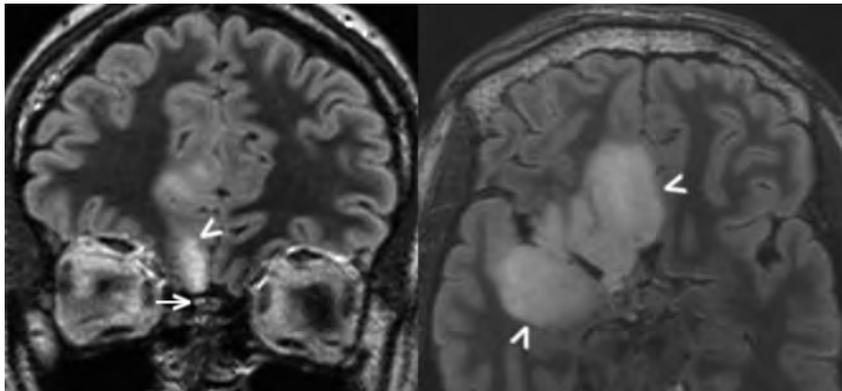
A 31-year-old man originally treated for right frontal lobe grade III anaplastic astrocytoma 6 years prior and now presenting with tumor transformation to an *IDHI*-mutant, 1p19q-codeleted GBM (case 12). Coronal and axial FLAIR images on re-presentation demonstrate a bulky nonenhancing masslike signal abnormality involving the right olfactory cortex (arrowheads) and olfactory nerve (arrow), compatible with GBM involvement.
